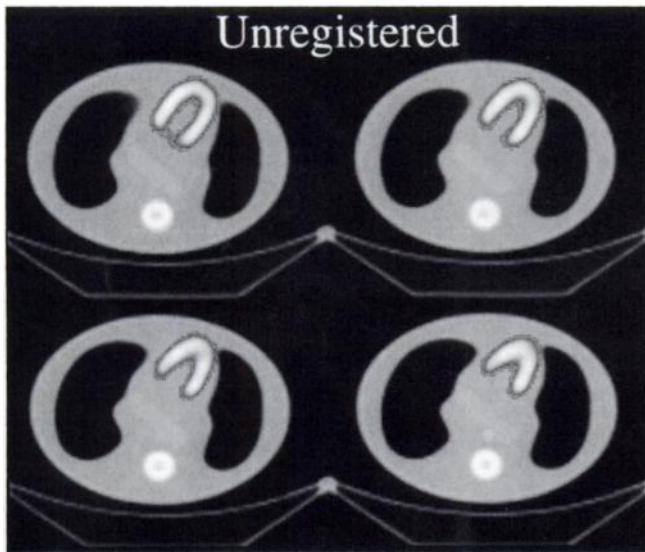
Transverse slices of unregistered SPECT images overlaid on CT images.
